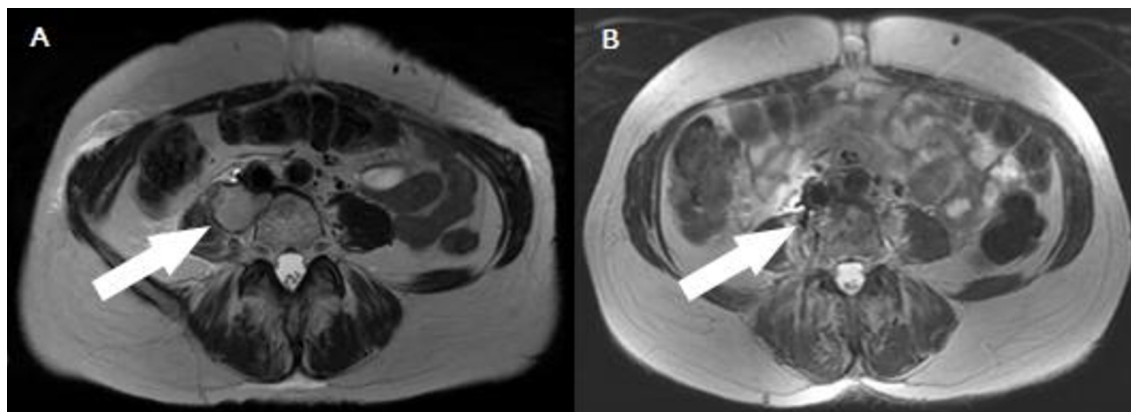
Axial image of MRI exam of October 2022 showing right pelvic mass (narrow A); exam of March 2023 with partial response of the lesion (narrow B).
